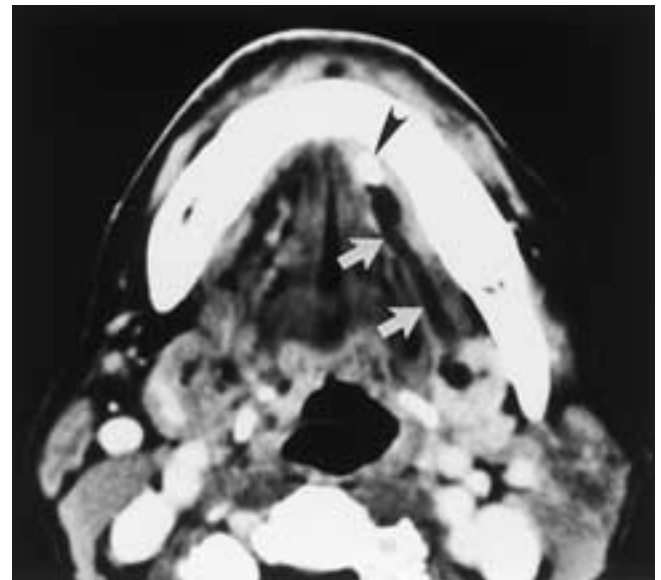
Distal submandibular duct calculus with marked duct dilatation. Contrast-enhanced axial CT scan demonstrates a distal calculus in Wharton's duct (arrowhead) and marked dilatation of the entire duct (arrows).
